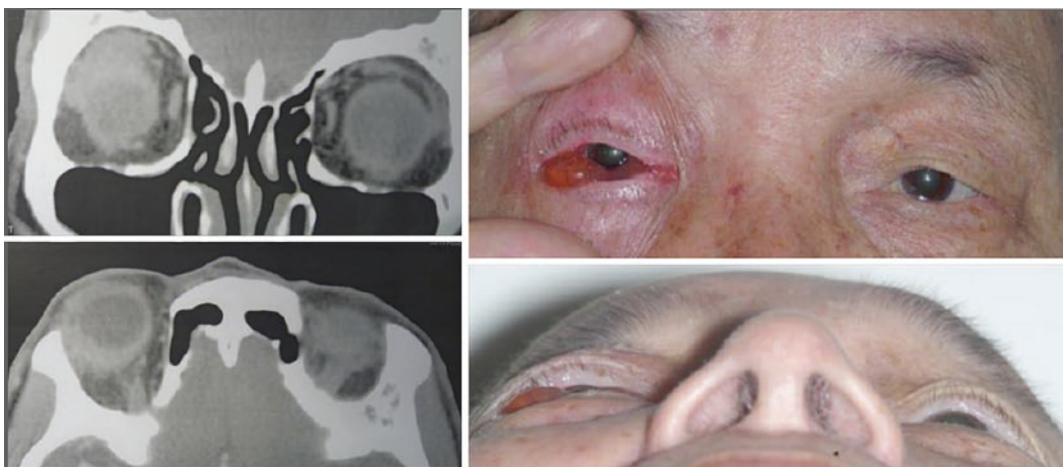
Idiopathic dacryoadenitis, myositis and anterior orbital involvement of IOI. CT showing swelling of right superior rectus/levator complex, lacrimal gland and thickening of the scleral uveal rim. Clinically patient presented with right periocular swelling, ptosis, chemosis and mild proptosis
